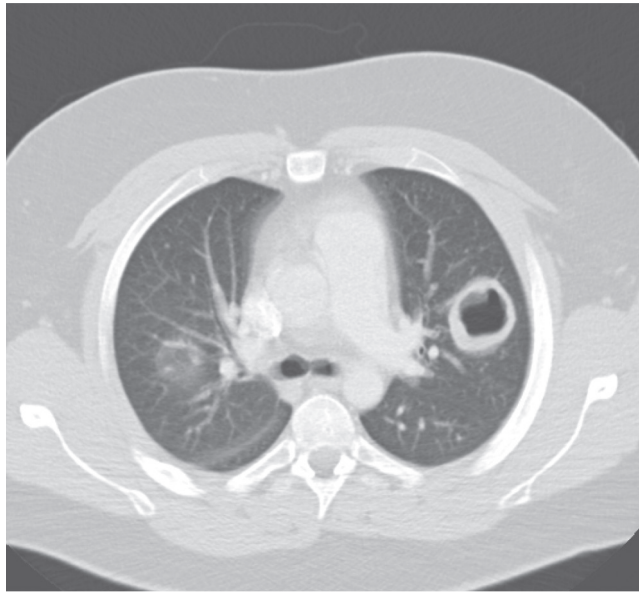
■ Computed tomography of the chest from a young man with Wegener granulomatosis. Central necrosis in a granulomatous lesion has the appearance of a cavitary lesion. Many other such lesions were present throughout the lung parenchyma.
